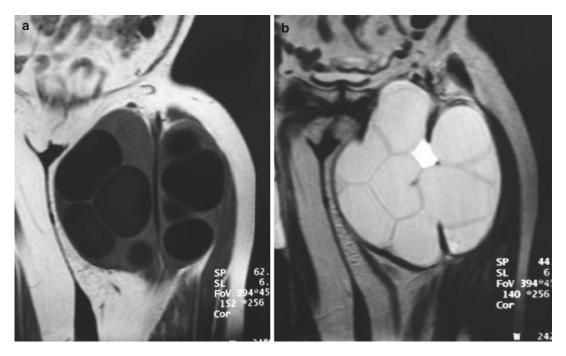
Multicystic echinococcosis of the left thigh. Coronal T1-WI (a) and T2-WI (b) MRI shows multivesicular hydatidosis of adductor space
